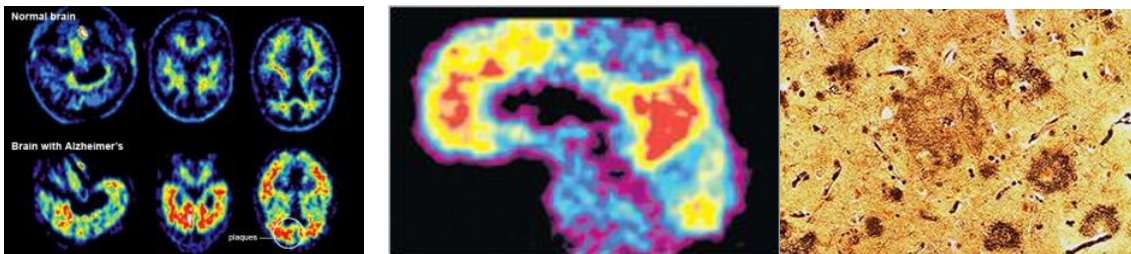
amyloid plaques MRI image of amyloid plaques in brain
